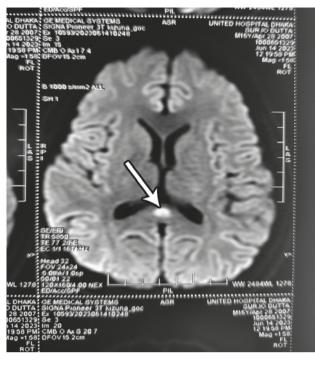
MRI brain of patient showing cytotoxic lesion of corpus callosum ( arrow marking)
